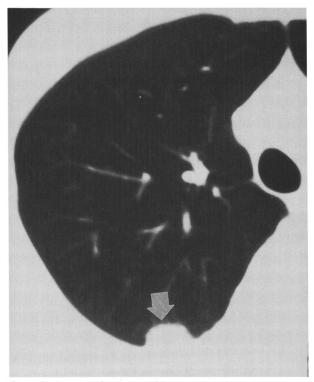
Computed tomographic scan showing a 2-cm uncalcified amyloidoma in the right upper lobe abutting the pleura (arrow).
